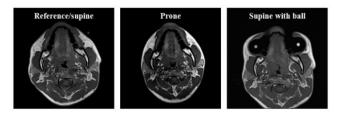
MRI slices of the head in the reference (supine) position, prone position and supine position with balls placed inside the buccal cavity.
